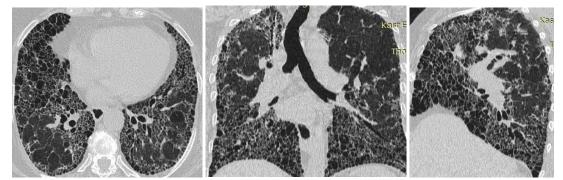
65 years old male with cough, fever and dyspnea. Axial, coronal reformatted and sagittal image shows ill defined ground glass attenuation mainly peripheral, honeycombing, reticulations, interlobular septal thickening with traction bronchiectatic and bronchiectatic changes. CT picture suggesting of UIP.
